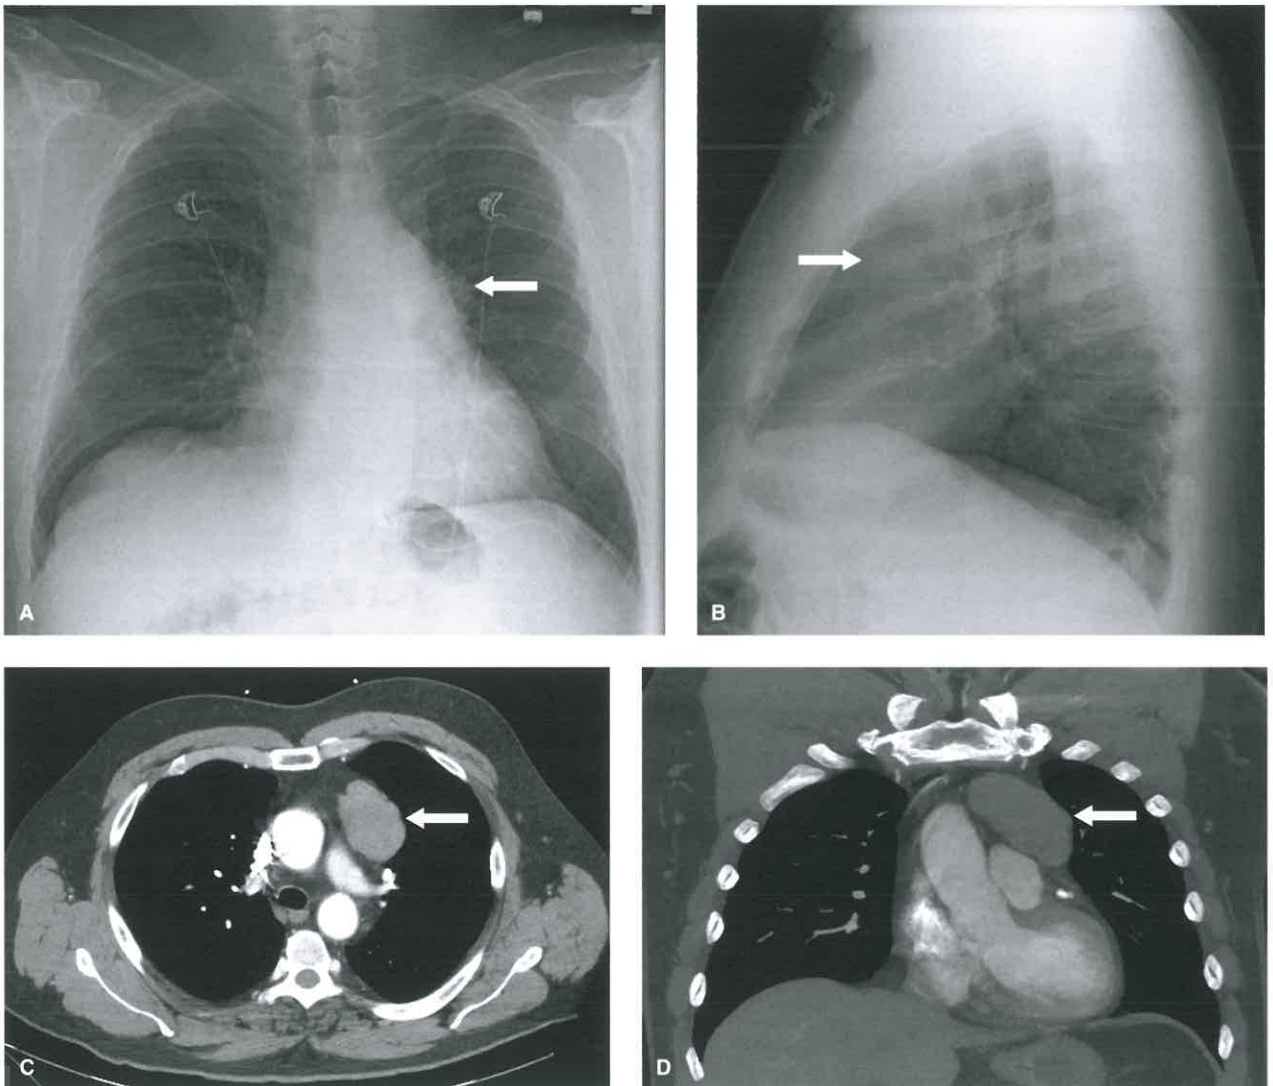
Noninvasive Thymoma. A: Chest radiograph shows a left anterior mediastinal mass (*arrow* in A). B: Lateral radiograph confirms the anterior location of the mass (*arrow*). C, D: Axial (C) and maximum intensity coronal (D) contrast-enhanced CT scan shows a lobulated left anterior mediastinal mass (*arrows* in C, D). Surgical resection revealed a noninvasive thymoma.
